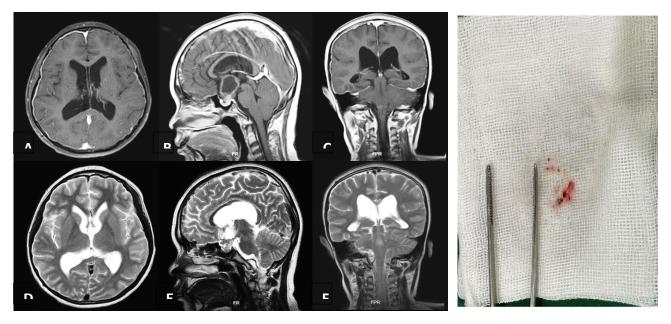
MRI brain of Case no. 1. (A) T1 axial with contrast, (B) T1 sagittal with contrast, (C) T1 Coronal with contrast, (D) T2 axial, (E) T2 Sagittal, (F) T2 Coronal, (G) Mass of Tumor Removal from case no. 1
